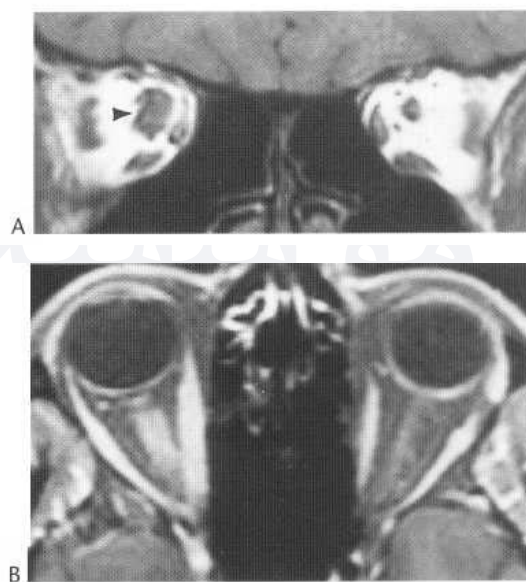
Optic nerve meningioma. Coronal T₁-weighted MR image (A) demonstrates marked thickening of right optic nerve sheath (arrowhead). Axial T₁-weighted postcontrast fat-saturated image (B) demonstrates peripheral enhancement of the thickened right optic nerve sheath. Non-enhancing soft tissue within represents the encased optic nerve.
